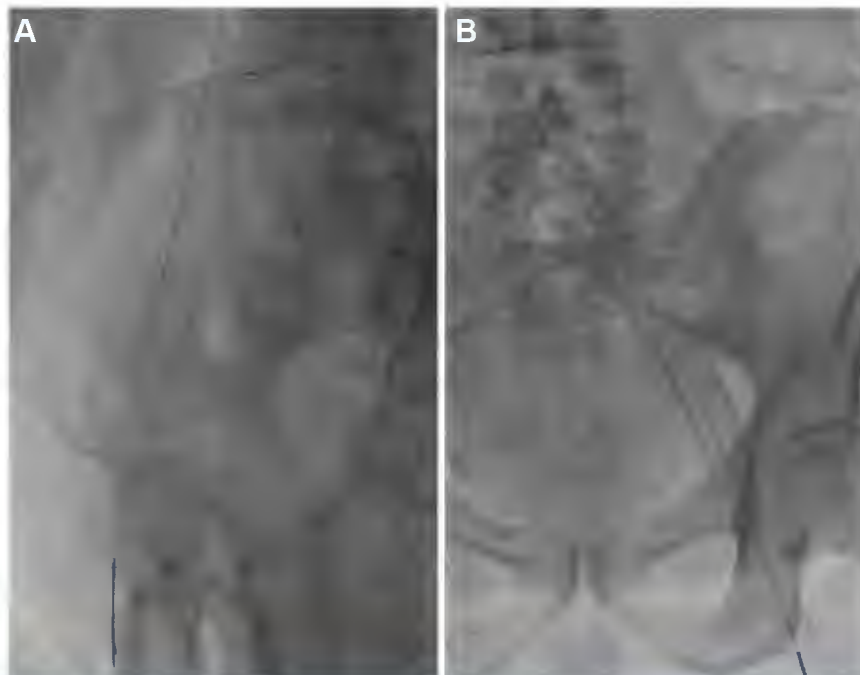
A, Lateral radiograph demonstrating the smooth tapering of a woven stent after deployment (Wallstent). Stent sculpting was carried out with dilation of the common iliac portion of the 20-mm stent with a 24-mm angioplasty balloon to overcome stent compression and create an adequate outflow channel. B, Anteroposterior view of another example of stent sculpting. Here a 22-mm Wallstent was angioplastied with a 24-mm angioplasty balloon.
